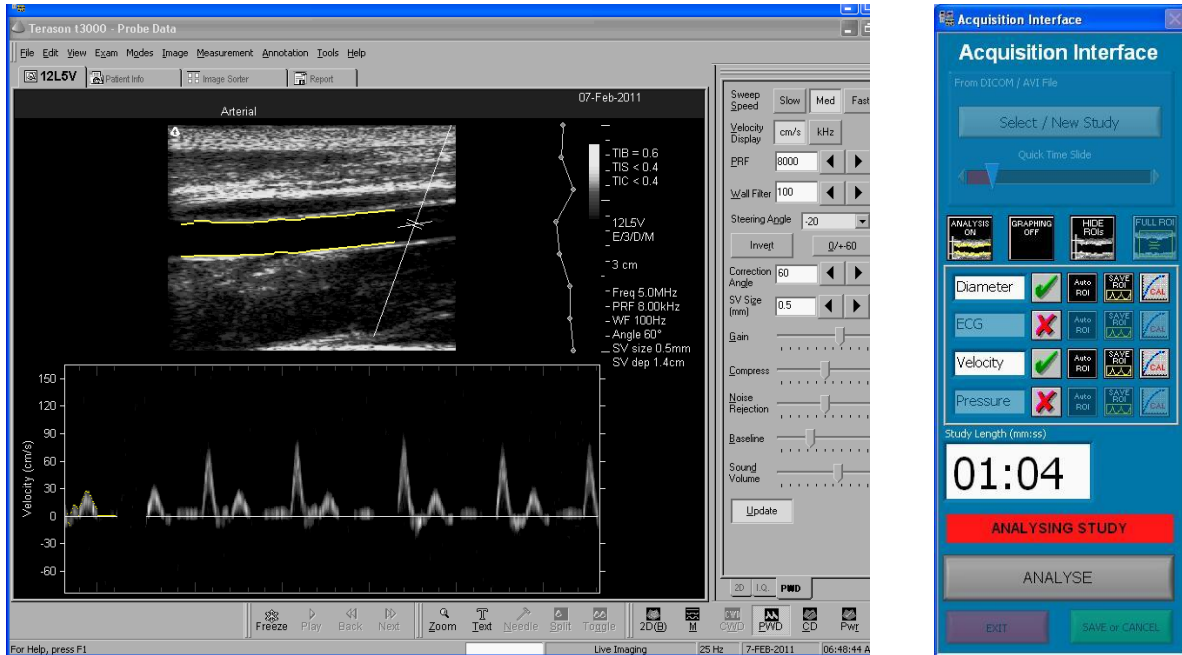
Video analysis interface. The right portion displays the acquisition interface where the user can select the region of interest of the 2D image and the Doppler trace. The top half of the screen highlights the region of interest selected for the software to detect the wall of the vessel. Below is the Doppler trace of the vessel where blood flow velocity is shown.
